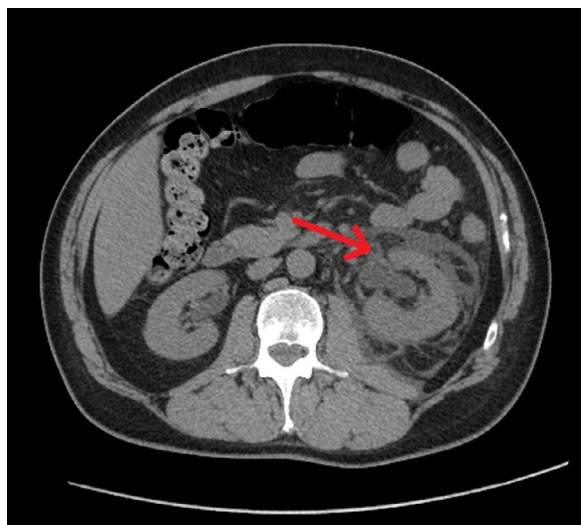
Abdominal CT in axial plane showing, at the point indicated by the arrow, retroperitoneal free fluid around the left renal pelvis and in the anterior perinephric space. CT, computed tomography.
